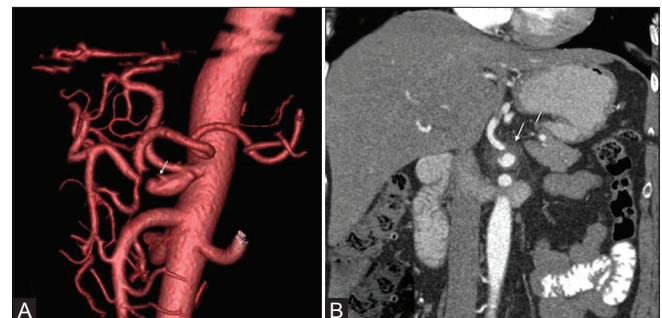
(A, B): Dissecting celiac artery aneurysm. (A) CT 3D VR image shows celiac aneurysm with true lumen (arrow) and occluded proximal splenic, hepatic arteries. (B) Coronal CT shows peri-celiac fat infiltration (arrow)
